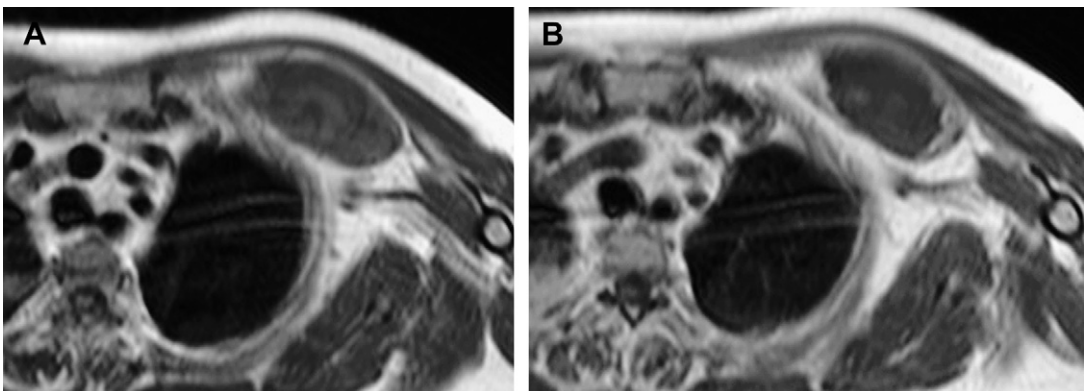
Intramuscular hematoma. (A) Axial T1-weighted image demonstrates a circumscribed low signal intensity hematoma in the pectoralis minor muscle in this patient on anticoagulation therapy. (B) Axial T1-weighted image following intravenous administration of gadolinium shows peripheral nodular enhancement.
